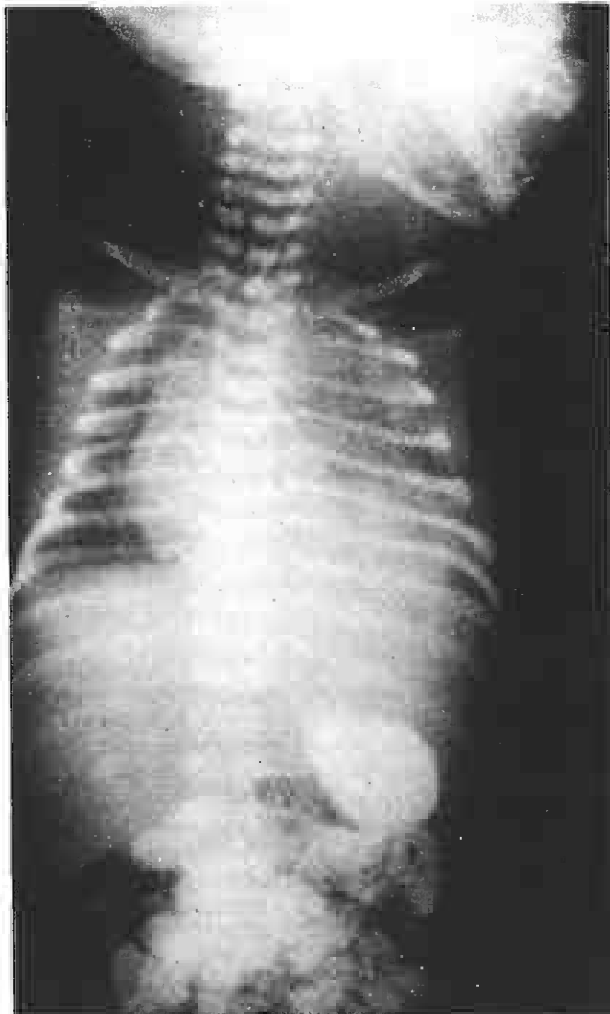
X-ray film with contrast showing radiolucent areas visualised in the initial portable x-ray film were not loops of intestine.
